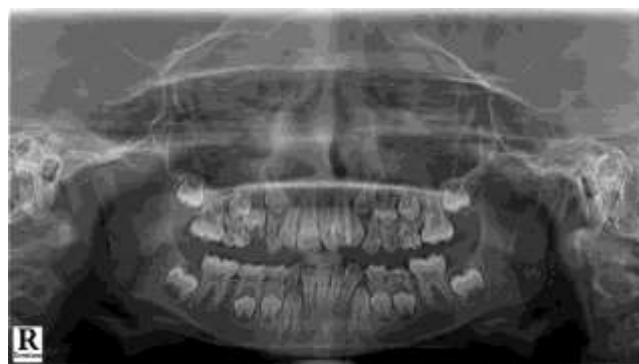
Panoramic radiograph of a patient with rotation wrt 22
